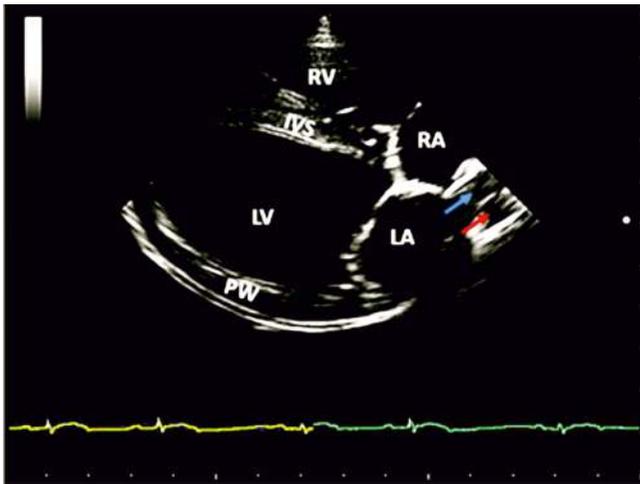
Right parasternal four-chamber view (RV-right ventricle, RA-right atrium, LV-left ventricle, LA-left atrium, IVS-interventricular septum, PW-left ventricle posterior wall, the blue arrow-right pulmonary vein, the red arrow-right main pulmonary artery)
